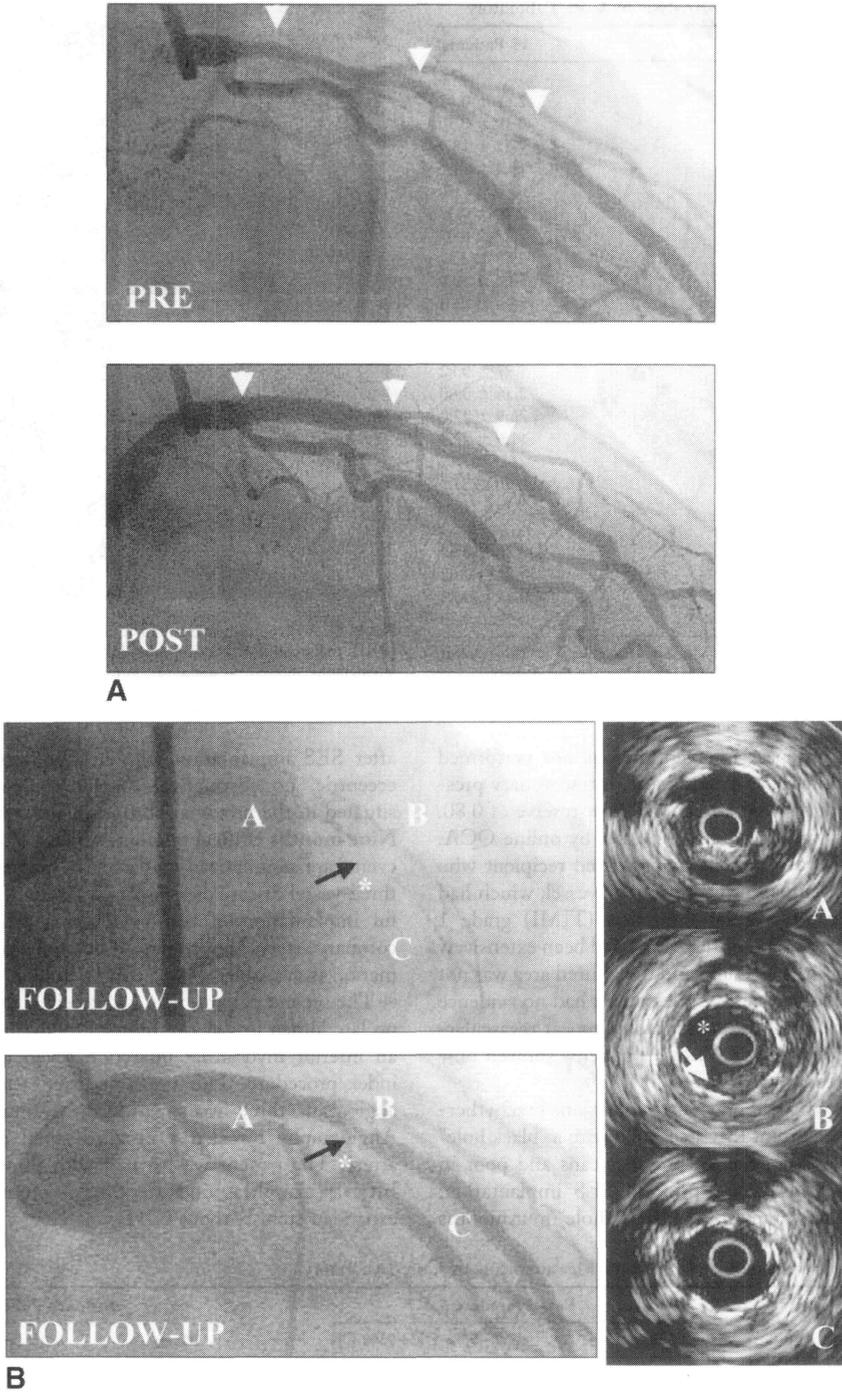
(A) Angiograms: the long proliferative in-stent restenosis (ISR) (PRE) was treated with two sirolimus eluting stents (SESs) (POST). The follow-up angiogram showed focal-repeat ISR (62% DS) in the gap (arrow), which was not covered by the SES. No neointimal hyperplasia (NIH) was evident in the two SESs (A and C). (B) Intravascular ultrasound (IVUS): follow-up IVUS showed no NIH in the proximal (A) and distal (C) SES with images of two layers of stent struts. Neointimal hyperplasia was noted in the gap region (B) where only one layer of (bare) stent struts can be seen. * indicates the position of the IVUS catheter at the gap segment.
